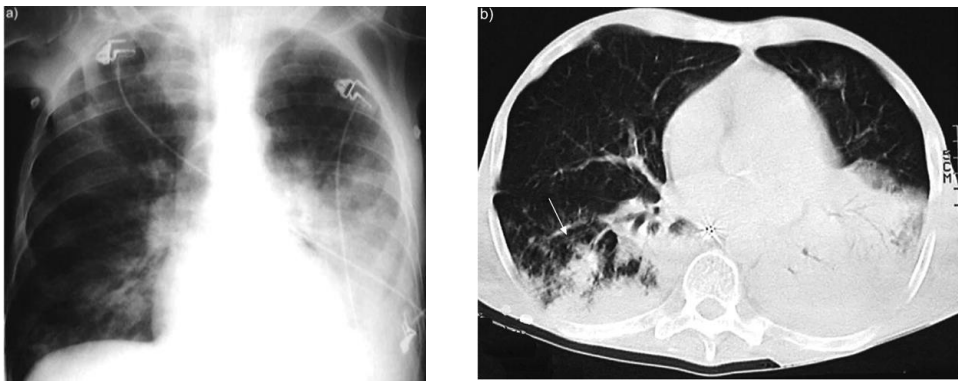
Invasive aspergillosis present in a patient with COPD visualised by a) chest radiograph, b) computed tomography scan of the thorax (Bulpa P et al Eur Resp J 2007;30:782).
